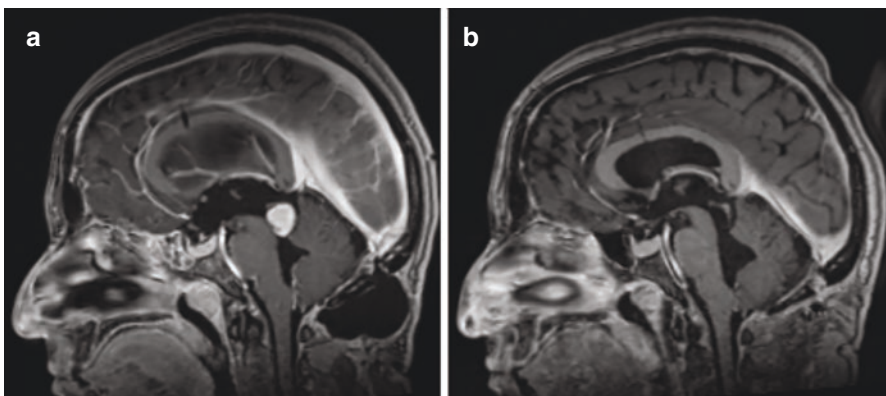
(a) Pre- and (b) postoperative magnetic resonance imaging (T1WI after contrast delivery) of an aqueductal WHO grade II ependymoma
